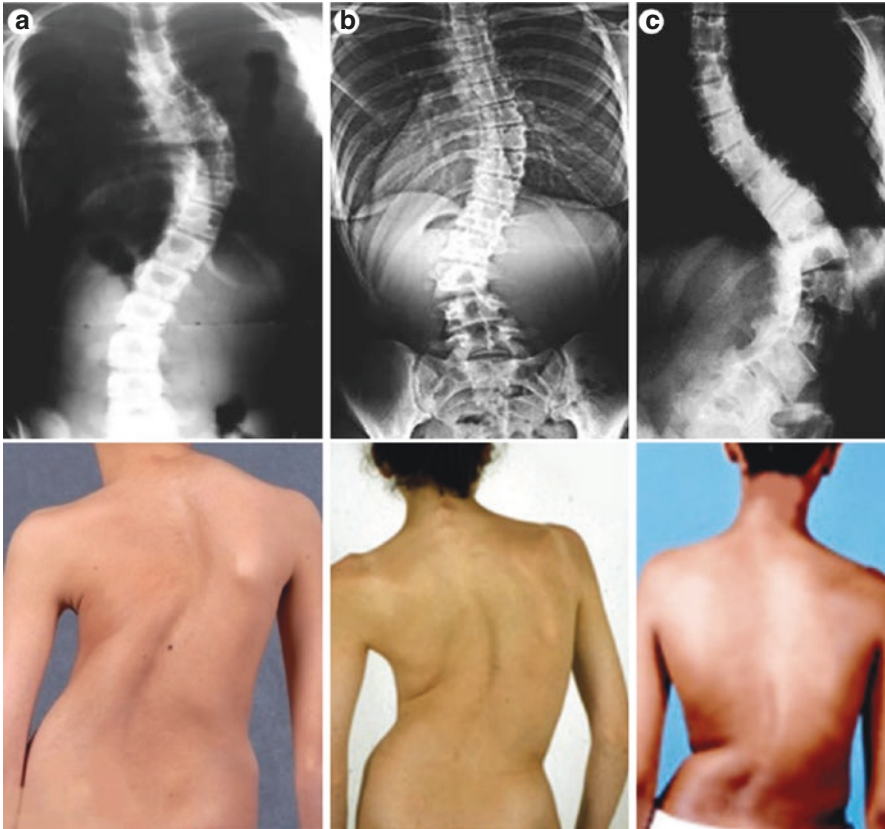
Three curve types based on location of curve. Posterior-anterior standing radiographs of patients (top row) with corresponding clinical photograph (bottom row). (a) Right thoracic. (b) Thoracolumbar. (c) Lumbar. From *Cheng et al.* 2015, Fig. 2, page 4 [3]
